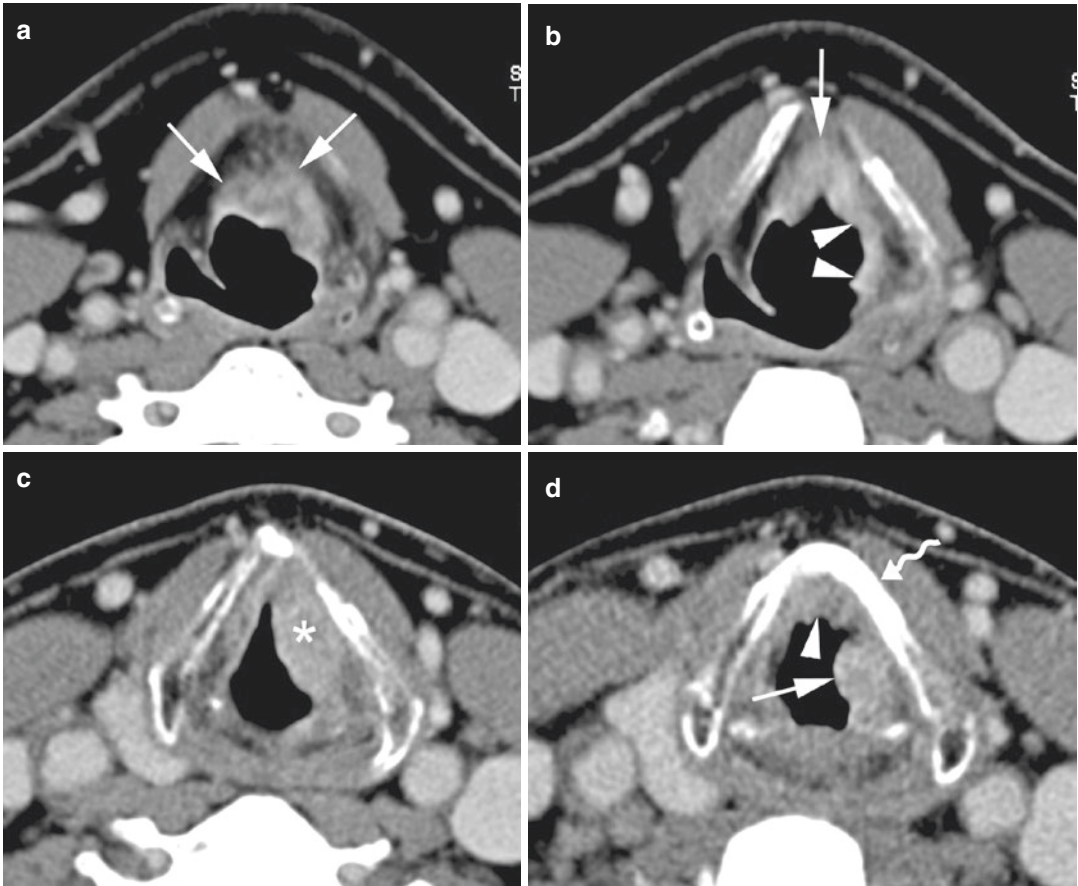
Contrast-enhanced CT images in a patient with supraglottic squamous cell carcinoma. (a) Axial image. Thickening and increased enhancement of the infrahyoid epiglottis, with infiltration of the preepiglottic space (arrows). (b) Axial image, more inferiorly, shows downwards tumor extension along the epiglottis and preepiglottic space (arrow), as well as posterolateral growth into the aryepiglottic fold. (c) Axial image, more inferiorly, shows tumoral infiltration of the left false vocal cord. (d) Axial image, level of ventricle entrance. Tumoral soft tissue thickening just above the level of the anterior commissure (arrowhead), as well as just above the level of the true
